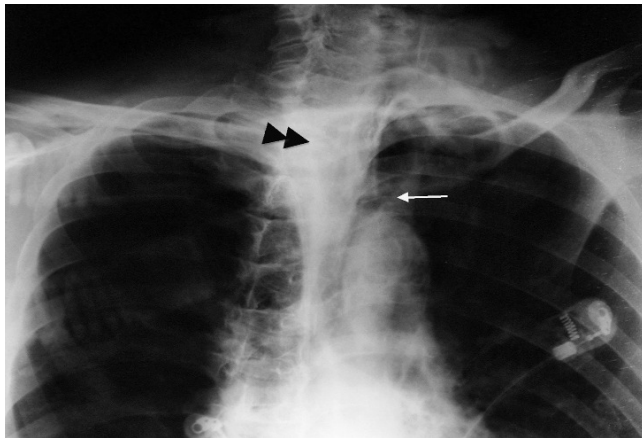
Chest X-ray showed oval shaped air density 4 cm in diameter (arrowheads) surrounding tracheal cannula (white arrow).
